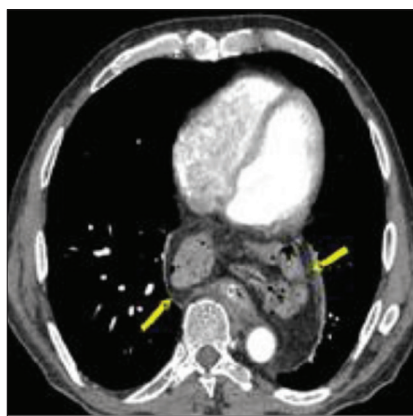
Axial computed tomography image showing isolated intrathoracic colonic herniation (yellow arrows)
